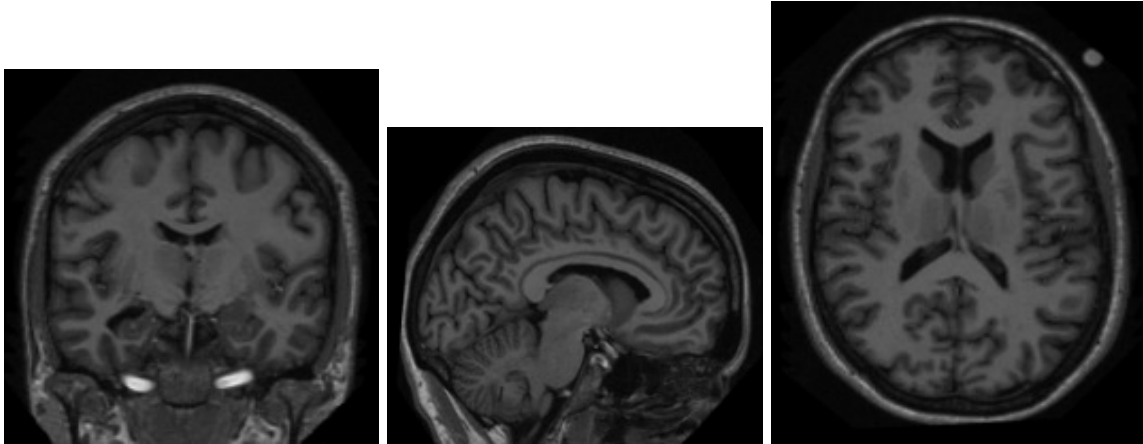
Front, Side and Top MRI Scans for Patient 58
